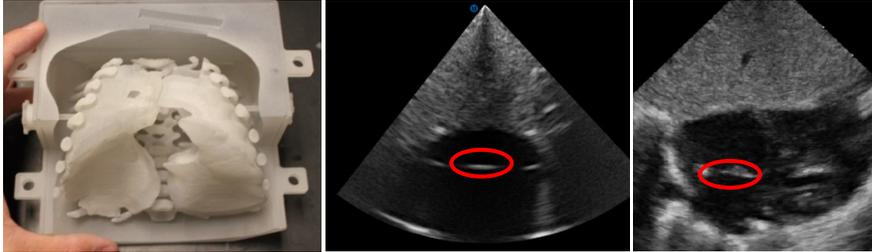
Image to the left represents a 3D printed replica of an infant torso generated from anatomic data. The middle image is the ultrasound image through this manikin once filled with tissue mimicking media. The image to the right is an ultrasound image of a human neonatal atrial septum which shows how similar the artificial replica mimics the human condition.
